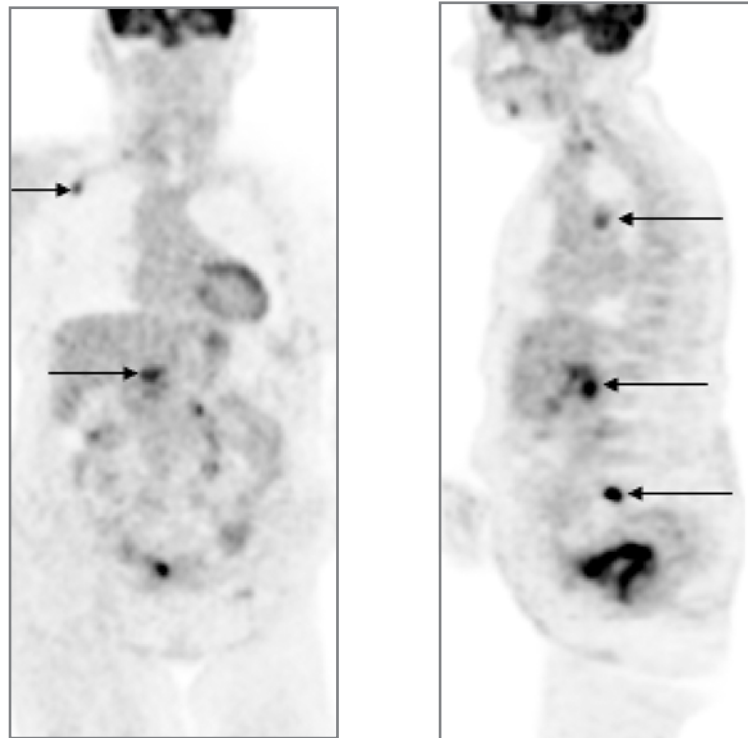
A 79-year-old women with carcinoma of the cervix and known involvement of the left ureter was treated with surgery and radiotherapy and considered to be cured. Nine years later, she presented with gross hematuria. CT showed a complex mass at the vaginal vault, and the biopsy was negative. A PET was performed to assess local and possible metastatic disease. The coronal (*left*) and sagittal (*right*) FDG-PET images showed widespread metastases (*arrows*) including the right pectoral region, the lung hilum, the porta hepatis, and retroperitoneal lymph nodes in the abdomen. Biopsy confirmed metastatic disease.
